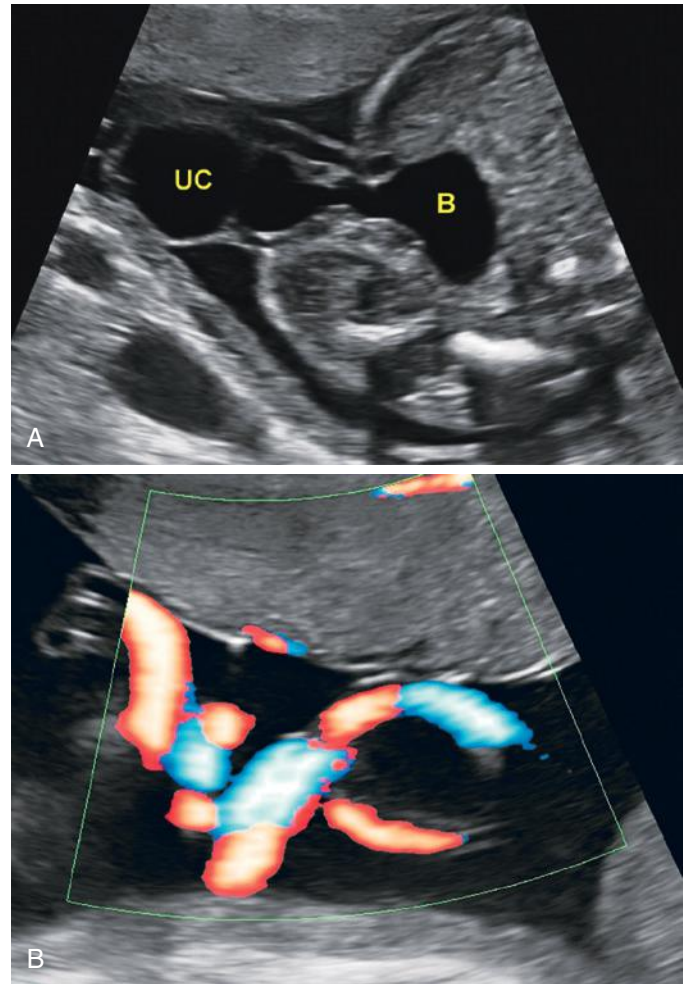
Urachal cyst. A, Sonolucent urachal cyst (UC) at the ventral aspect of the fetus, near the cord insertion. Initially, this lesion may resemble an omphalocele without prolapsed organs or soft tissue. On closer examination, the cyst can be seen to communicate with the fluid-filled urinary bladder (B). B, Color Doppler ultrasound image shows characteristic splaying of the umbilical arteries on either side of the urachal cyst. The urachal remnant was easily repaired with surgery done shortly after birth.
